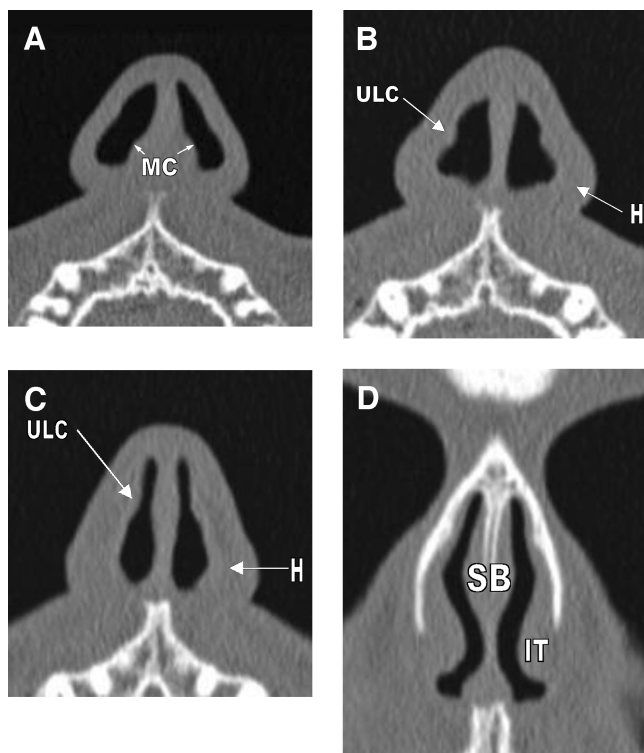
Modified coronal CT reconstructions, at various angles to the horizontal, to approximate perpendicular orientation to direction of airflow. (A) Thirty degrees from horizontal plane, at the nasal valve inlet. The septocolumellar junction is widened by the medial crura (MC) of the lower lateral cartilages. (B) Forty-five degree angle from the horizontal plane, proximal cartilaginous valve segment, showing mild inward deflection of the upper lateral cartilage (ULC) and the hinge area (H), which contains sesamoid cartilages and poorly supported soft tissues. (C) Sixty-degree orientation from horizontal, distal cartilaginous valve region, anterior to piriform aperture. Inward curvature of ULC can significantly impinge on the airway at this level. H area has thick, poorly supported soft tissues. (D) Ninety degrees to the horizontal plane. Distal valve region—the bony segment. The nasal swell body (SB) is noted superomedially and the inferior turbinates (IT) are positioned inferolaterally.
